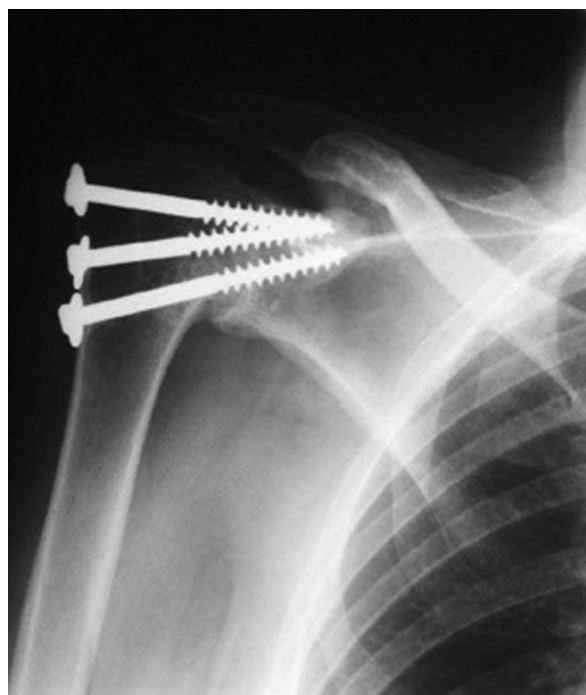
Preoperative radiograph demonstrates the glenohumeral fusion of patient 1.
